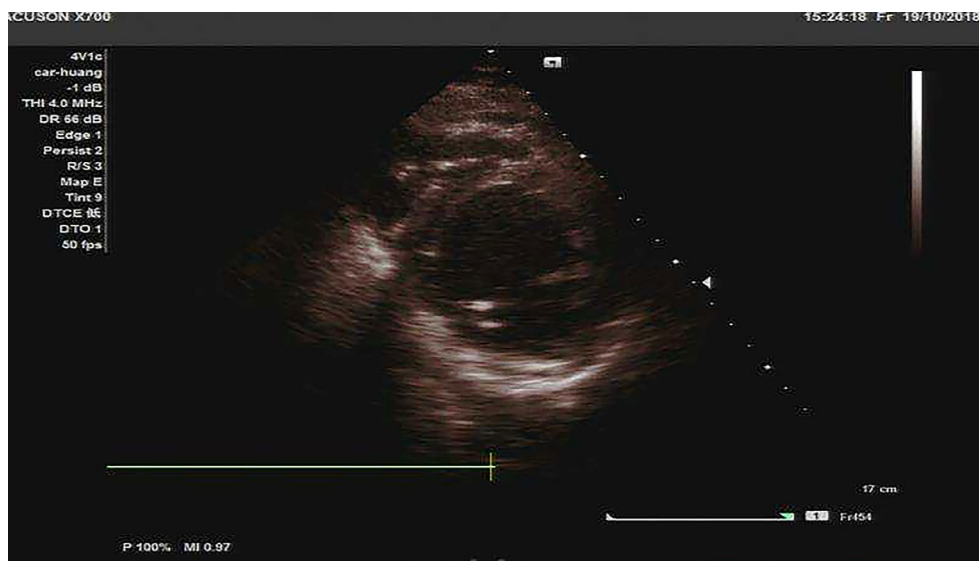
Echocardiographic parasternal short-axis view of ischemic cardiomyopathy.
